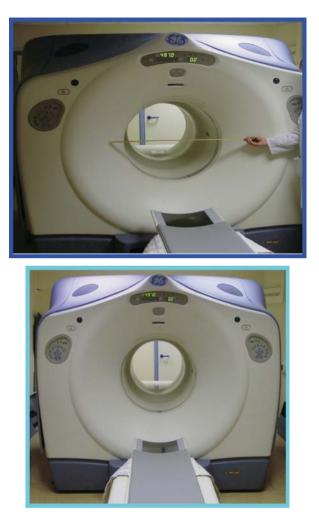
GE PET/CT scanner.
